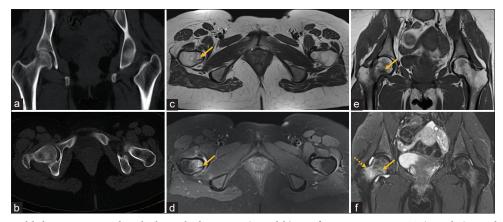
A 24-year-old doctor presented with the right hip pain. (a and b) No fracture seen on CT. (c and e) Axial and coronal T1W MRI images show focal linear hypointense line in the right femoral neck (arrow) representing fracture line. (d and f) Corresponding axial and coronal STIR images show corresponding hypointense fracture line (arrow) with surrounding hyperintense edema (dashed arrow). The patient was found to have elevated PTH, low calcium, and Vitamin D, leading to secondary hyperparathyroidism and resulting stress fracture.
